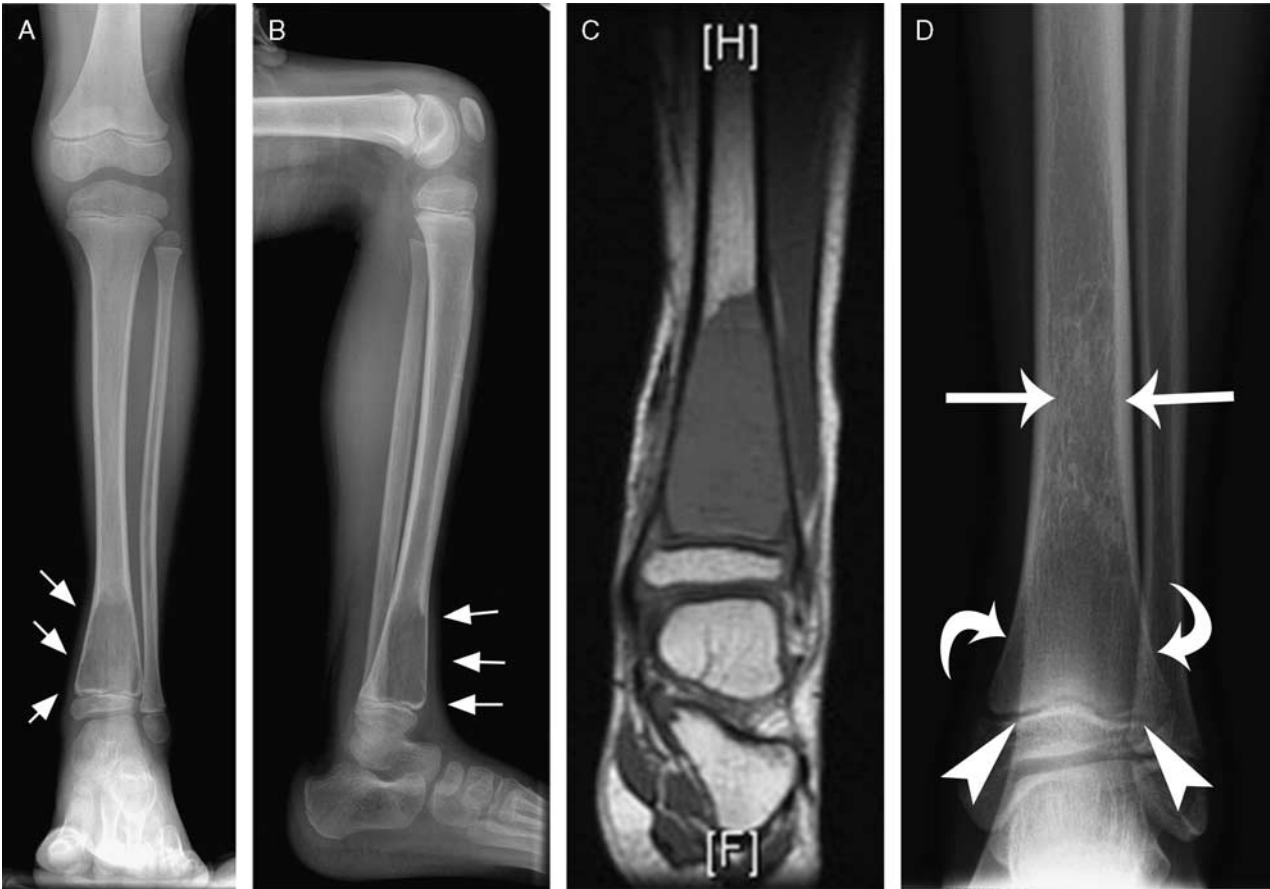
A 7-year-old boy with juxtaphyseal distal left tibial ABC with physeal involvement and no transphyseal invasion. Frontal (A) and lateral (B) radiographs of the left ankle demonstrate extensive metaphyseal juxtaphyseal ABC, with an expansile lytic area of bone destruction before treatment (arrows). C, T2-weighted coronal MRI demonstrates the extensive juxtaphyseal ABC with no transphyseal invasion. D, Anteroposterior left ankle radiograph 47 months following treatment demonstrates distal migration, cortical thickening, and healing of the lytic destructive ABC sites (arrows); in addition to return of the normal distal tibial metaphyseal concave morphology (curved arrows), and no evidence of physeal growth disturbance or deformity (arrowheads). ABC indicates aneurysmal bone cyst; MRI, magnetic resonance imaging.
